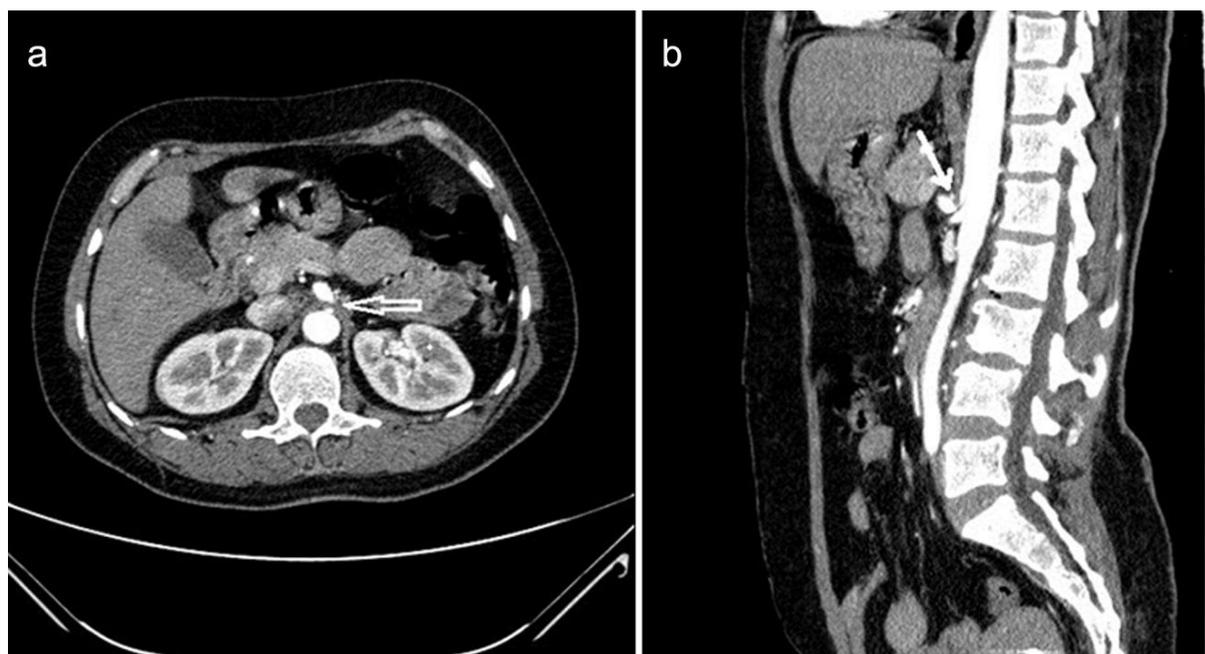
CT showing stenosis of the coeliac artery without any evidence of atherosclerosis
